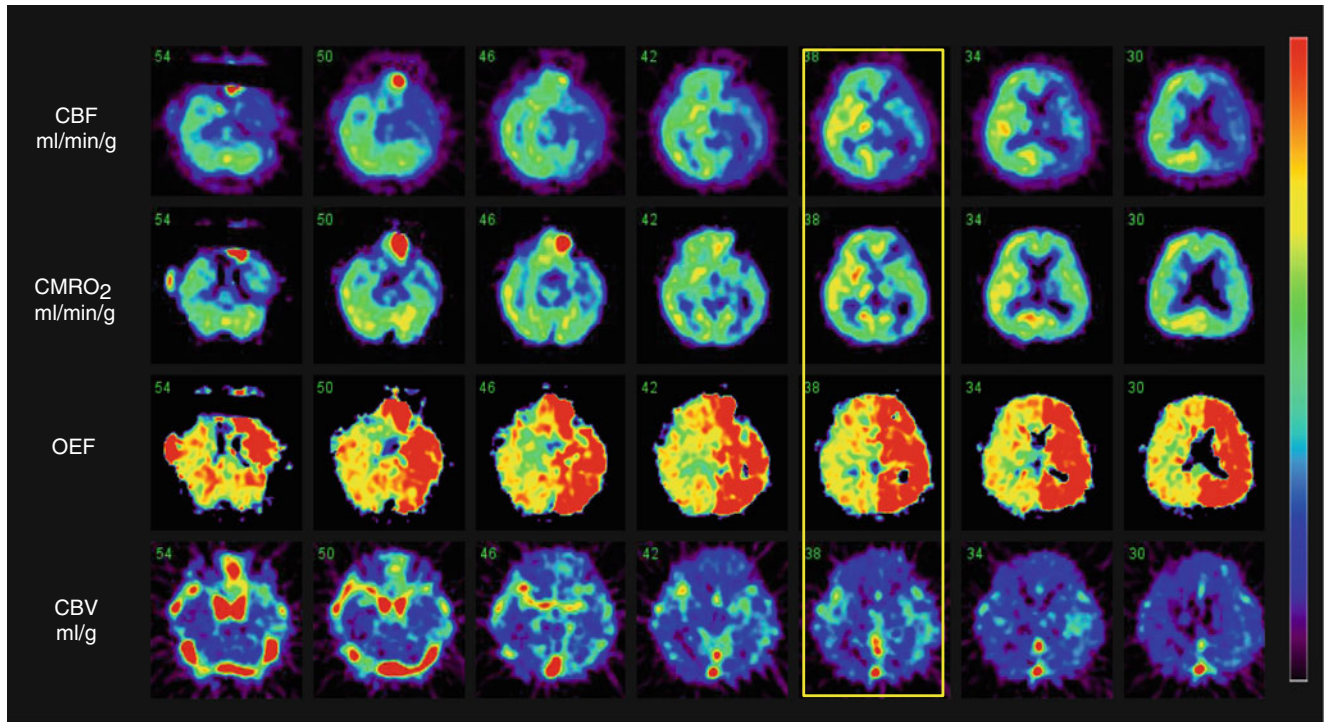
¹⁵O-gas PET of acute misery perfusion: this 61-year-old male suffered from right hemiplegia in progression. MRA on admission showed occlusion of the left common carotid artery. MRI demonstrated progression of infarction in the left centrum semiovale. ¹⁵O-gas PET on
